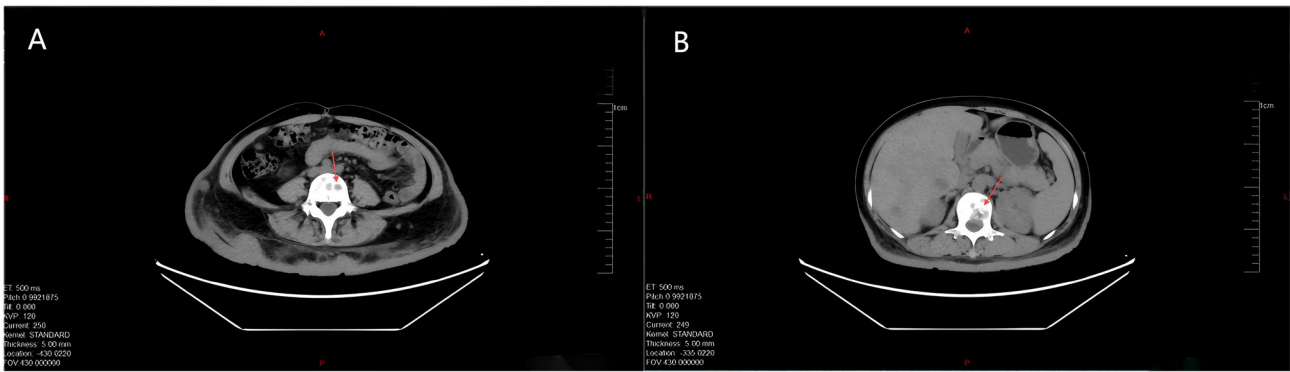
Multiple hypodense foci shown in lumbar vertebral bodies on abdominal CT (arrows indicate the bone metastasis focus). (A) Level of the renal hilum. (B) Level of the porta hepatis-upper margin of the pancreas.
